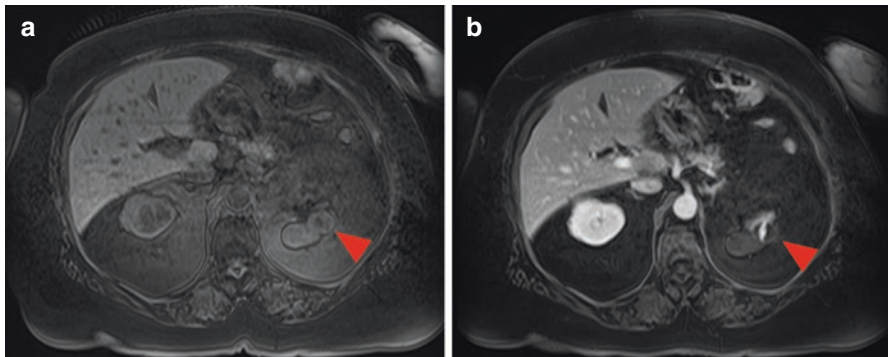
MRI images of a multi-lobulated Bosniak III cyst. (a) Axial, T1, fat-saturation, non-contrast image and (b) axial, T1, fat-saturation, post-contrast MR image. Note the thick, avidly enhancing septum in the lesion (red arrowheads)
